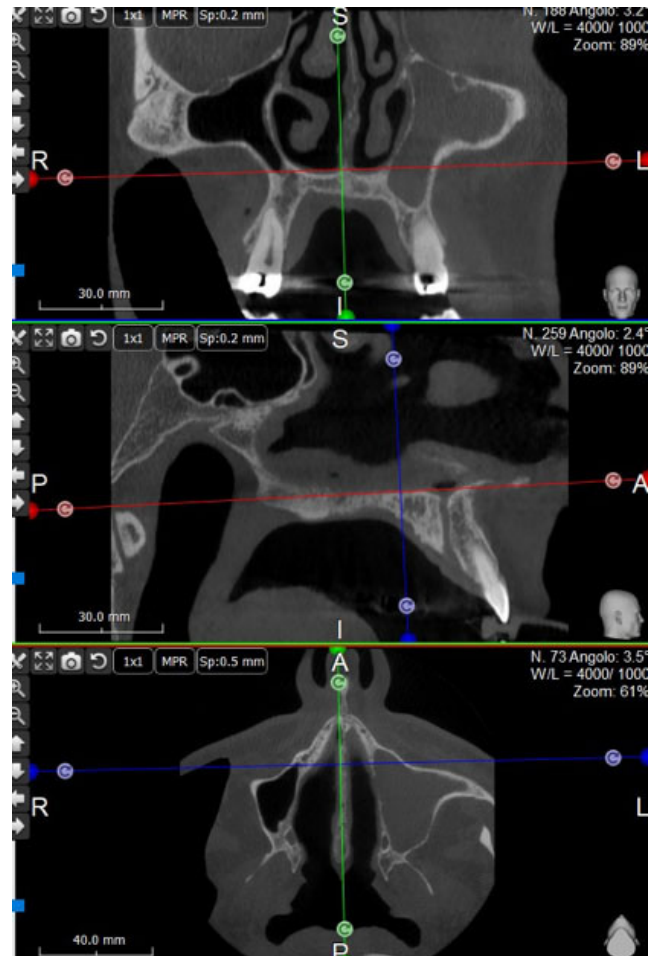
Tracking of SNA and SNP line in CBCT axial, sagittal and coronal view.
